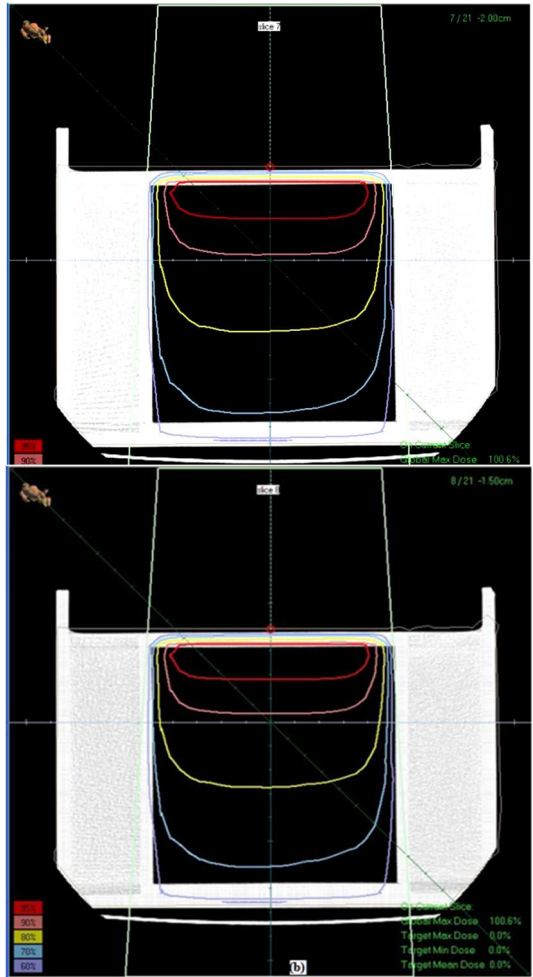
Two separate isodose curves (a, b) were obtained from two consecutive CT images from a cubic recipient (1000 ml) in TPS.
